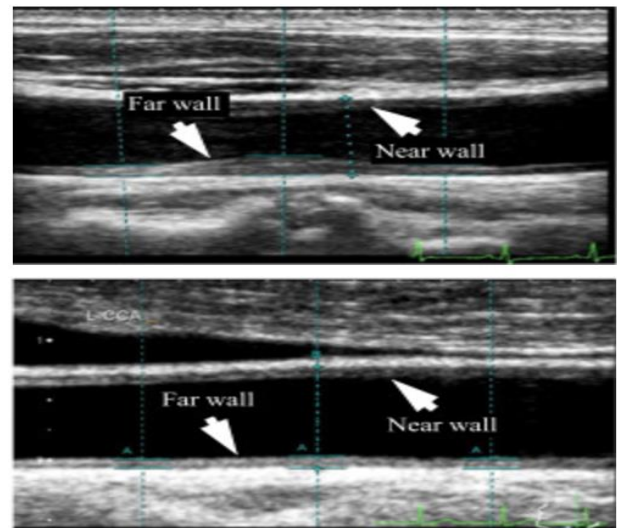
SAMPLE RAW IMAGES of B-Mode Ultrasound Corresponding to High Risk (left) and Low Risk (right) on the Basis of the Lumen Diameter Alone
